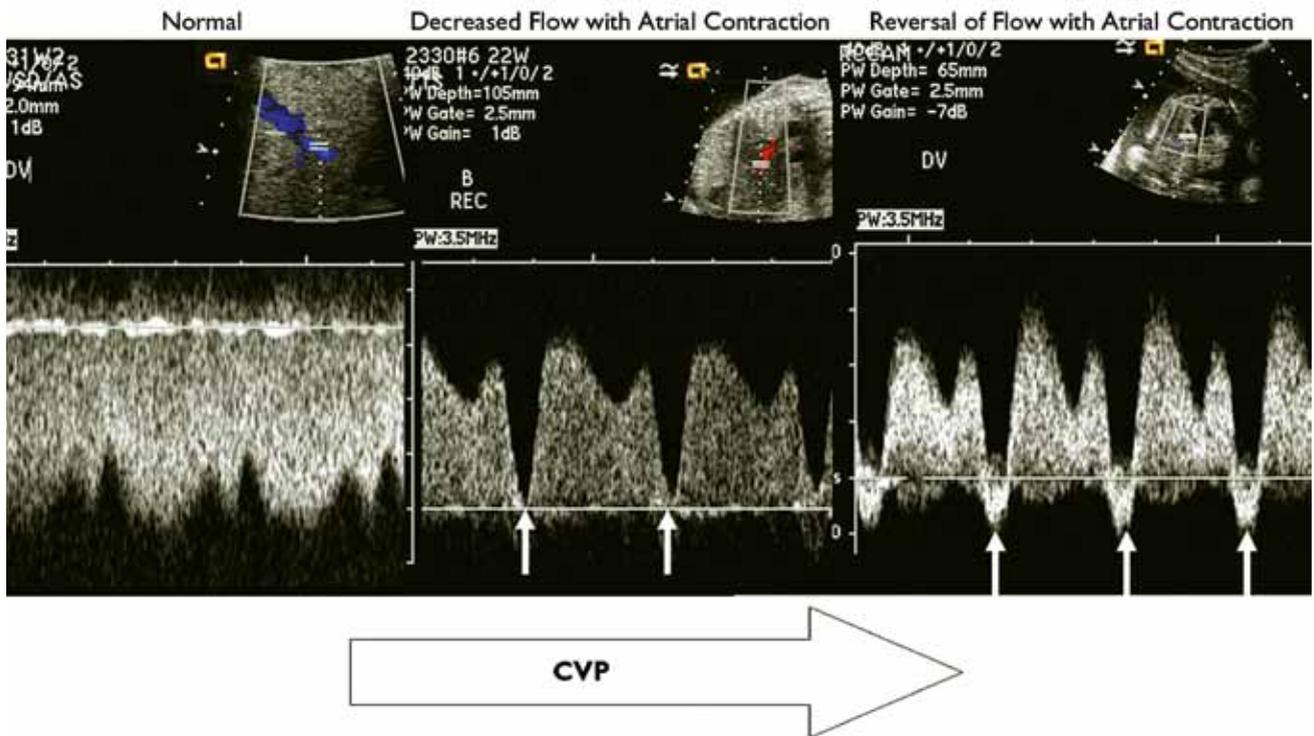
Ductus venosus (DV) Doppler flow patterns: the left-hand panel demonstrates the normal flow pattern. (This panel appears inverted because of the baby's position when the echo was obtained.) As central venous pressure increases, flow first returns to baseline with atrial contraction. Then there may be reversal of flow with atrial contraction. (With permission from Gleason M, ed. Pediatric Practice: Cardiology. New York: McGraw-Hill Medical; 2012. Chapter 3. Fetal Echocardiography.)
